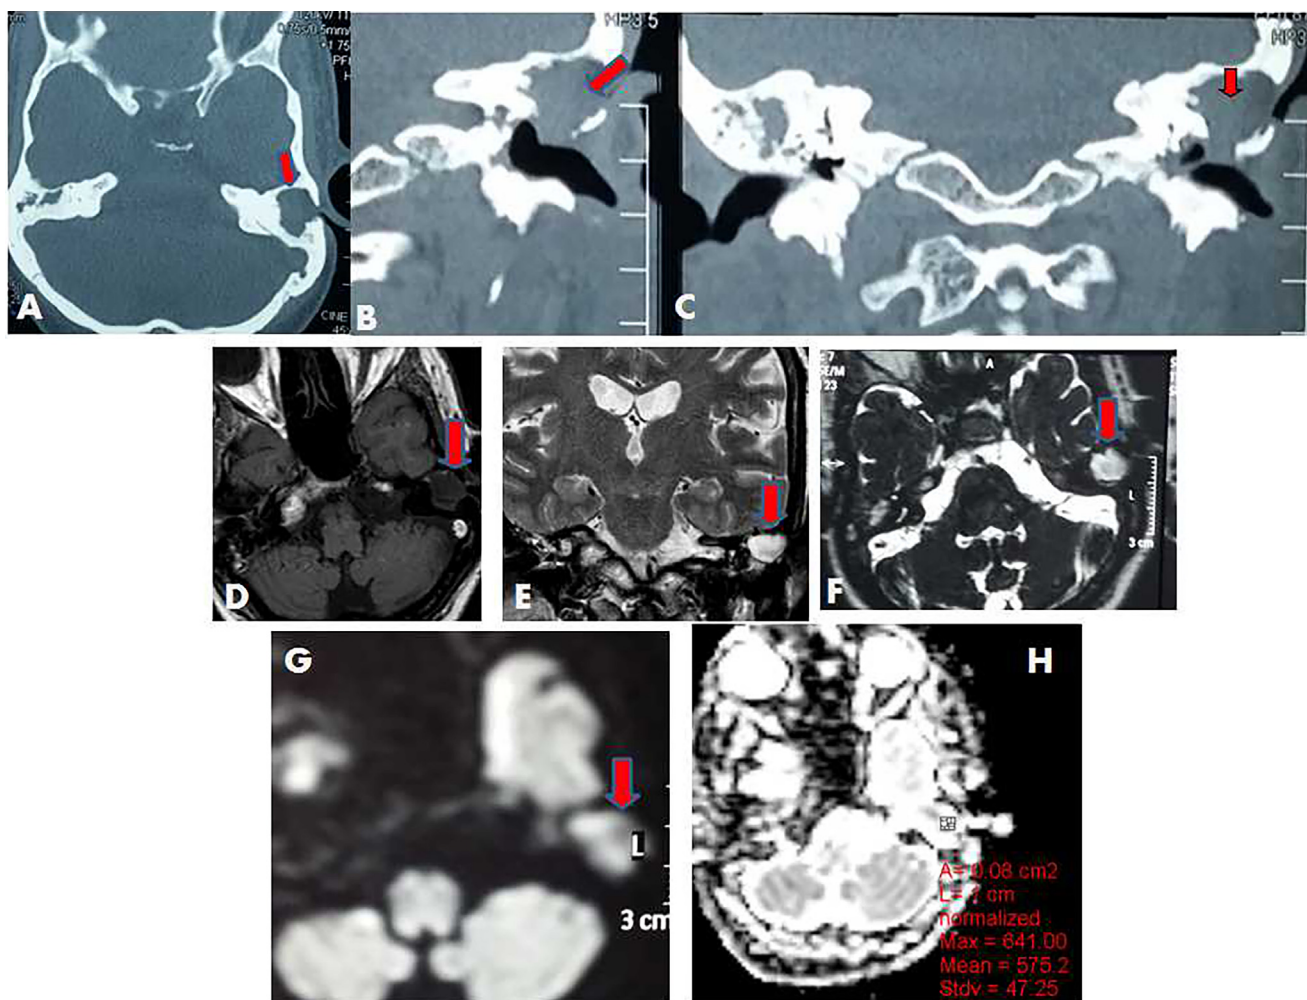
Recurrent cholesteatoma in the left middle ear of a 38 years old man who underwent canal wall up middle ear surgery. (A–C) Axial and Coronal CT cuts showed complete opacification of the left middle ear cleft (red arrow) with absent ossicles. (D) Axial T1WI, (E) Coronal T2W and axial (F) CISS MRI sequences showed a soft tissue lesion in the left middle ear cleft of low signal at T1WI and high signal intensity at T2WI and CISS (red arrow). (G) Axial DWI obtained with a b factor of 1000 s/mm² showed high signal intensity of the cholesteatoma (red arrow). (H) ADC (mean 575×10^{-3} mm²/s). The lesion size 16 mm, 9 mm.
